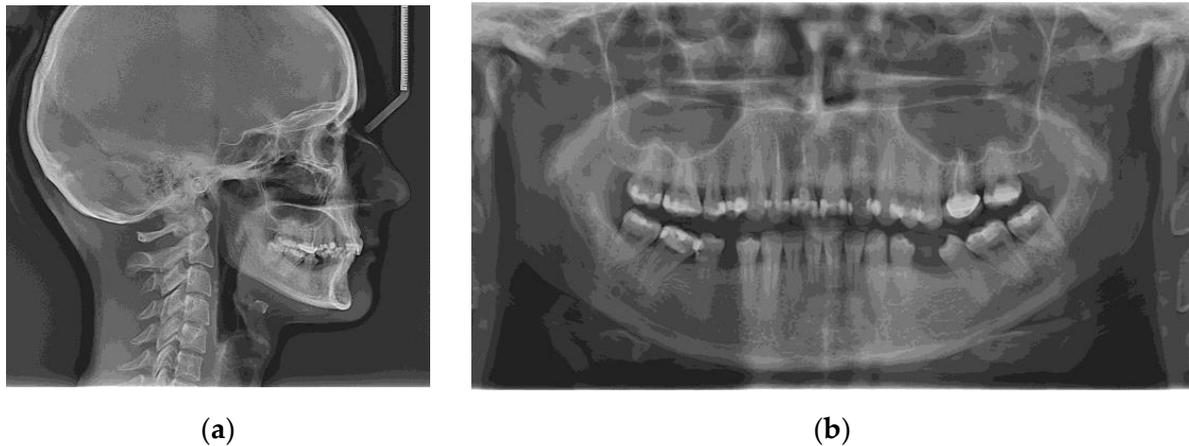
Radiographic examination before treatment: (a) Initial lateral cephalogram; (b) Initial panoramic radiograph.
